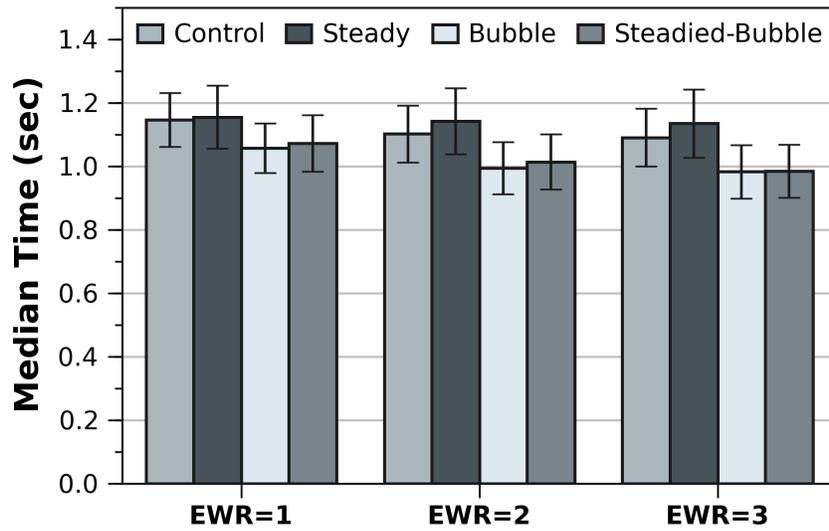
Average median trial time by *CT* and *EWR* ($N = 24$). Error bars are 95% confidence intervals.
